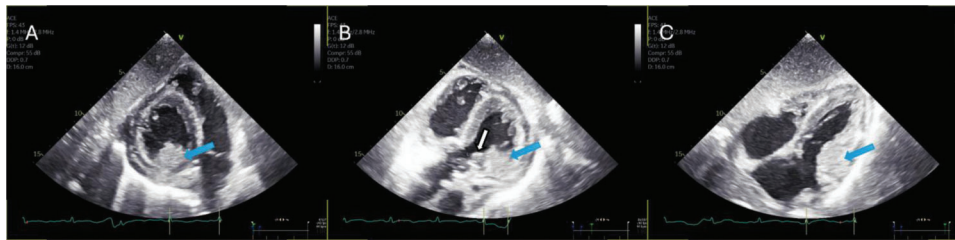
Patient 3 Echocardiographic images depicting cardiac metastasis. Panel A: Short-axis view from the subcostal window showing a subendocardial mass in the anterolateral segments from the basal to mid-myocardium (blue arrow). Panel B: Atypical five-chamber view highlighting another mass, likely a thrombus (white arrow), extending into the left ventricular outflow tract (LVOT) and passing through the aortic valve. Panel C: Four-chamber subcostal view demonstrating myocardial metastasis (blue arrow).
